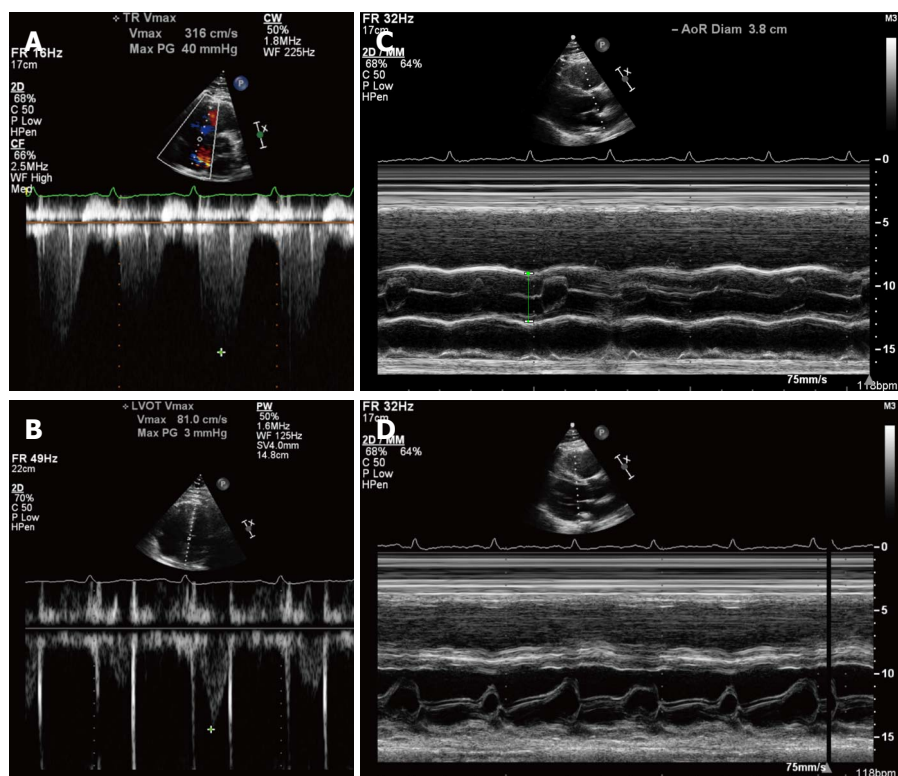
M-mode tracing. A: Beat to beat marked variation of continuous wave Doppler blood flow velocities of tricuspid regurgitation indicative of right ventricular pulsus alternans; B: Beat to beat marked variations of continuous wave Doppler blood flow velocities of left ventricular outflow tract indicative of left ventricular pulsus alternans; C: M-mode tracing showing beat to beat marked variation of aortic valve opening indicative of left ventricular pulsus alternans; D: M-mode tracing showing beat to beat marked variation of mitral valve opening indicative of left ventricular pulsus alternans.
